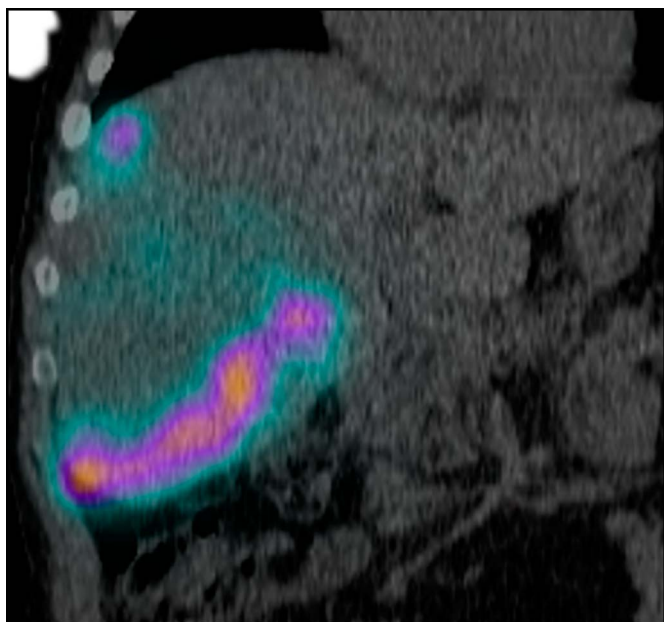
Single-photon emission computed tomography imaging after initial arterial mapping procedure.
